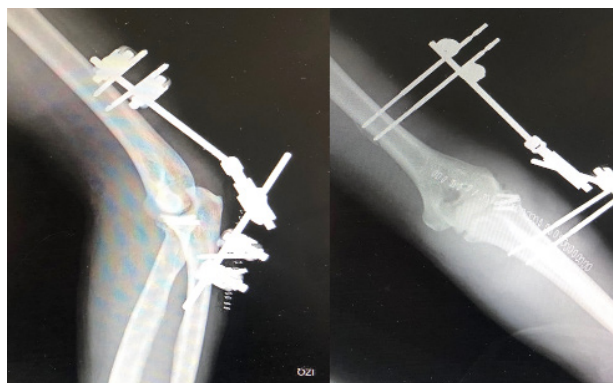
Postoperative X-ray control: lateral view (left); anteroposterior view (right).
